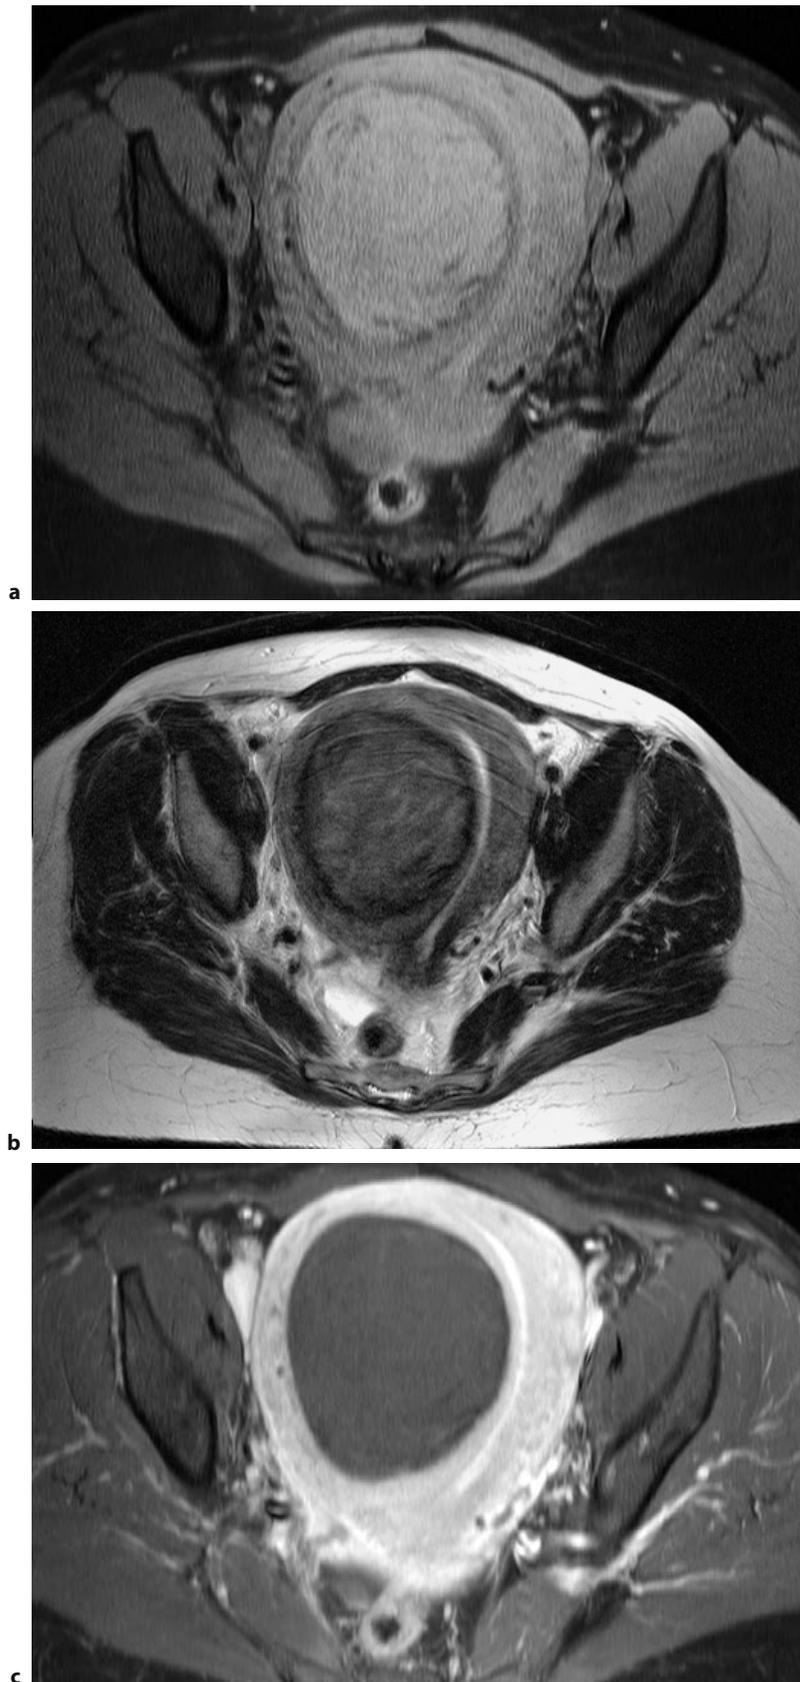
MRI of spontaneously infarcted leiomyoma. a T1-weighted fat-suppressed transaxial image of a spontaneously infarcted submucosal leiomyoma. The central portion shows a slightly hyperintense signal intensity compared to the surrounding myometrium. b T2-weighted transaxial image of a spontaneous infarcted submucosal leiomyoma. The central portion shows a signal intensity isointense to the myometrium while a marked hypointense rim is seen which corresponds to blood degradation products (hemosiderin) after hemorrhagic infarction. c Contrast-enhanced T1-weighted fat-suppressed transaxial image confirms infarction of the leiomyoma while the surrounding myometrium is well perfused (Reproduced with permission from [223])
